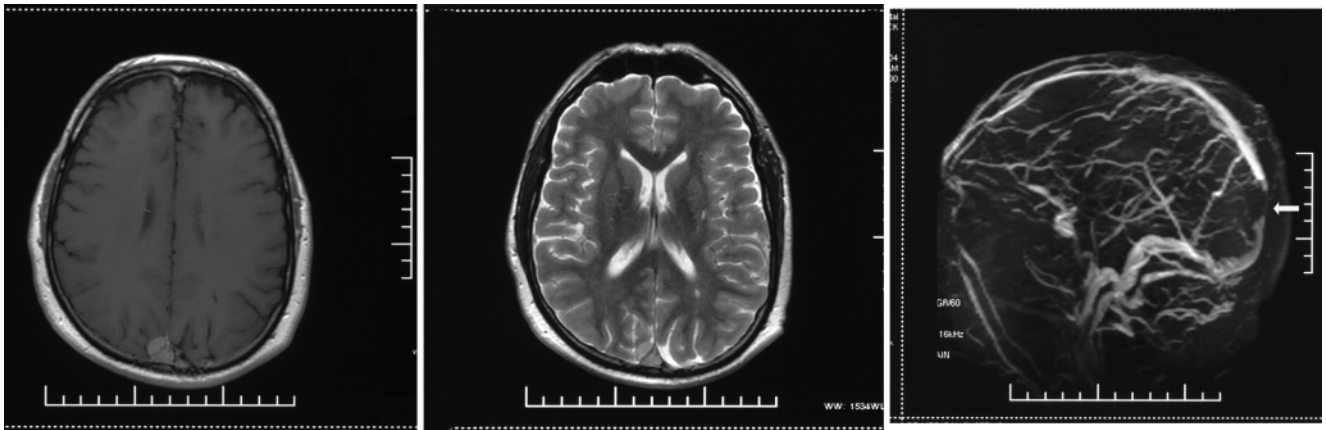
Preoperative images of the tumor in the SSS. Axial T1-weighted MR image after contrast administration (*left*) and a T2-weighted MR image (*center*) show the parasagittal tumor involving the SSS. An MR venogram (*right*) shows loss of signal in the posterior segment of the SSS at the site of the tumor (*arrow*).
